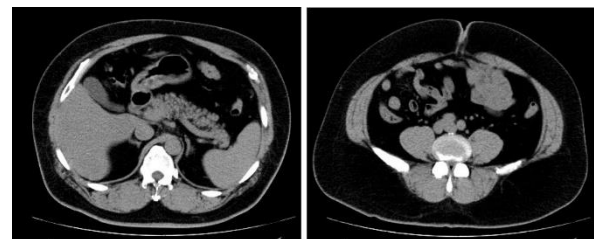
Findings of abdominal CT scan
